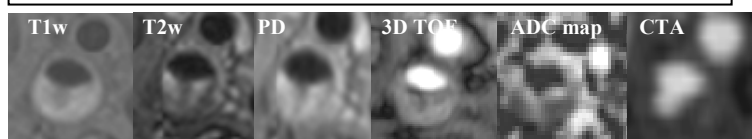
MRI sequences detailing carotid wall noted by the red arrows in figure 1.
